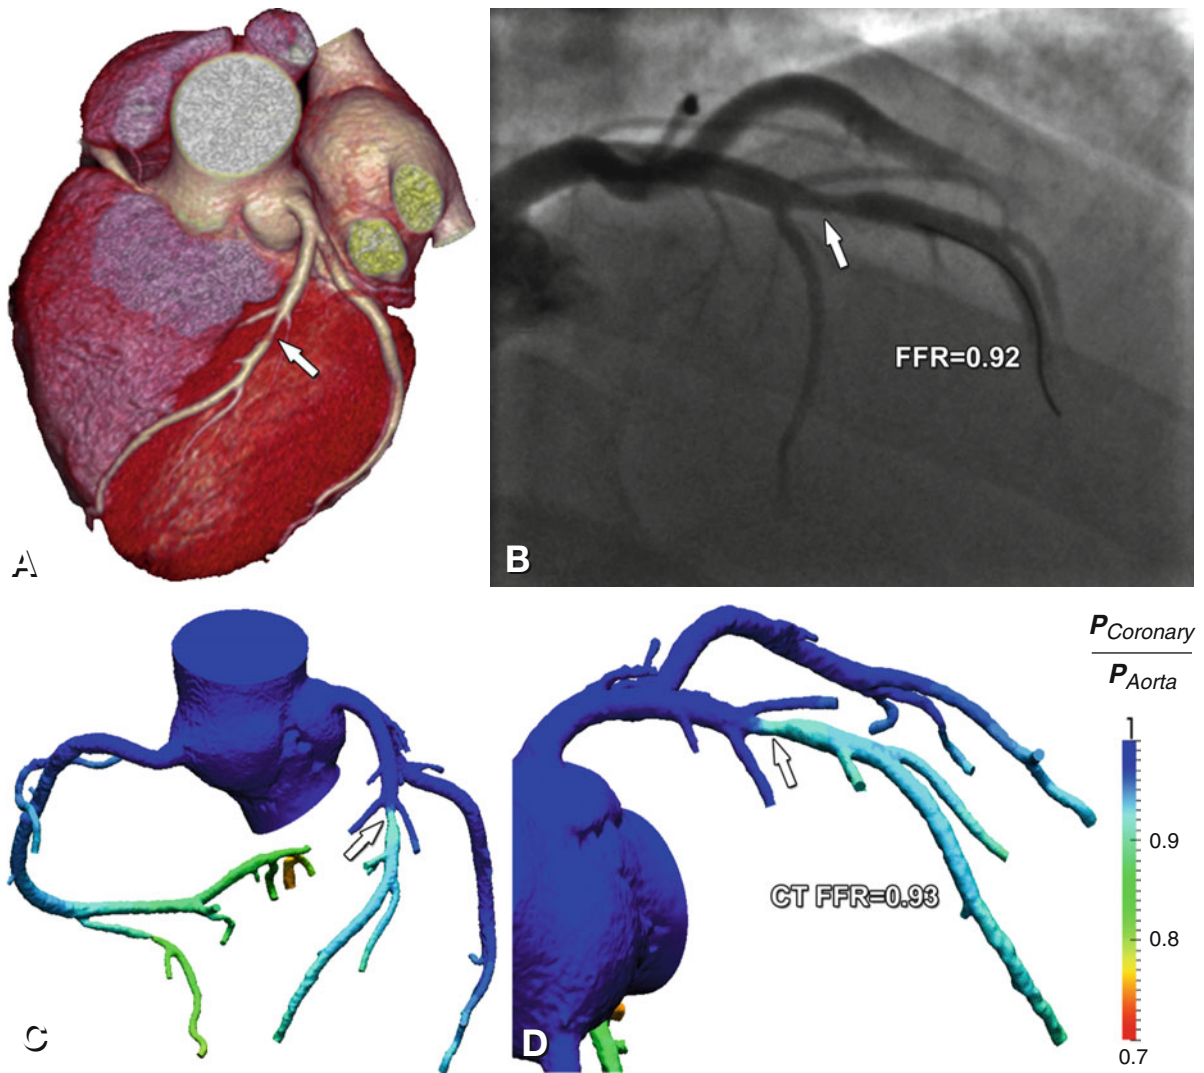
A case example of one of the first patients studied for CT FFR in 2009. This was a 60-year-old man with a 6-month history of intermittent exertional chest pain. Coronary CTA demonstrated a >50% stenosis in the left anterior descending artery (*arrow in Panel A*) and diagnostic angiography confirmed a 60% stenosis in the left anterior descending artery (*arrow in Panel B*). Computed FFR distal to the lesion was 0.93, indicating that this lesion did not cause ischemia (*arrows in Panels C and D*). This estimate was in good agreement with measured invasive FFR of 0.92. This patient was treated medically and had no coronary events during 3 years of follow-up
